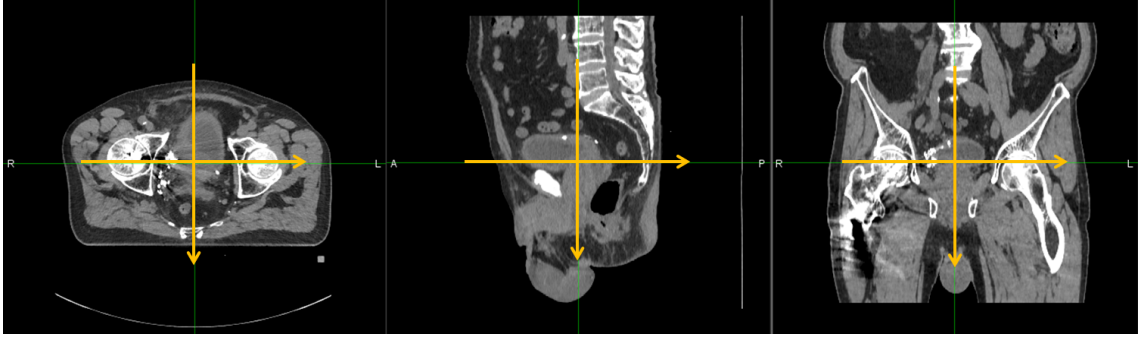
The coordinate system in the MIM<sup>®</sup> Software. The positive directions are indicated by the arrows. When performing an image registration, the planning CT image was chosen as the primary image. This means that in all the registrations, the CBCT image is moved according to the planning CT image.
